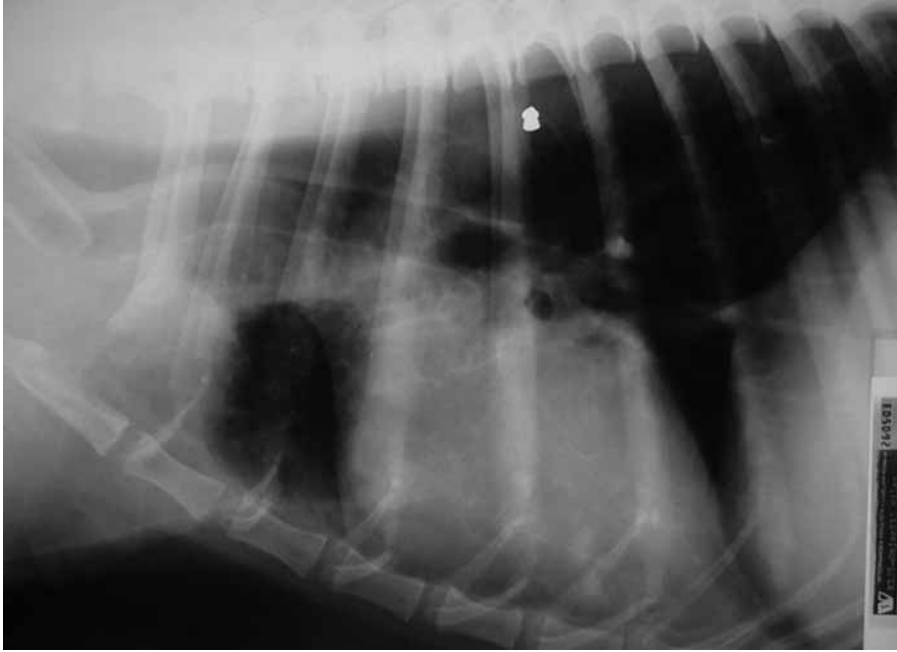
Survey right lateral thoracic radiograph: a marked localized interstitial infiltrate obscuring the pulmonary vessels in the right cranial lung lobe; borders are classified as alveolar in nature; radiopaque airgun projectile was found; nonradiopaque foreign body still suspected because of the infiltrate which develops around the affected bronchus
